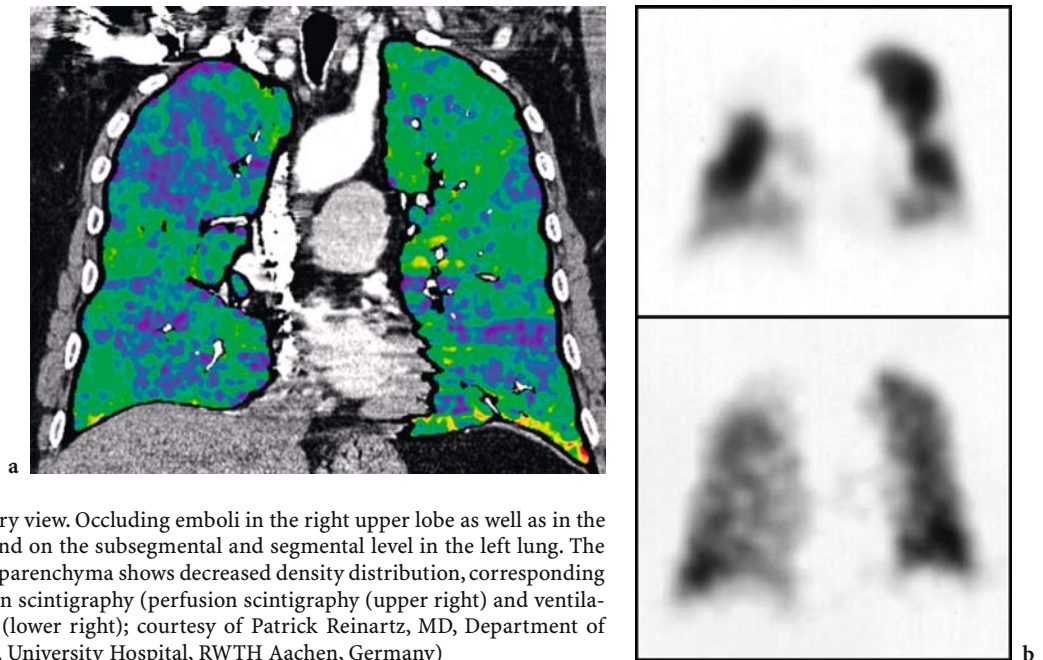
Coronal view. Occluding emboli in the right upper lobe as well as in the right lower lobe and on the subsegmental and segmental level in the left lung. The downstream lung parenchyma shows decreased density distribution, corresponding to the mismatch on scintigraphy (perfusion scintigraphy (upper right) and ventilation scintigraphy (lower right); courtesy of Patrick Reinartz, MD, Department of Nuclear Medicine, University Hospital, RWTH Aachen, Germany)
